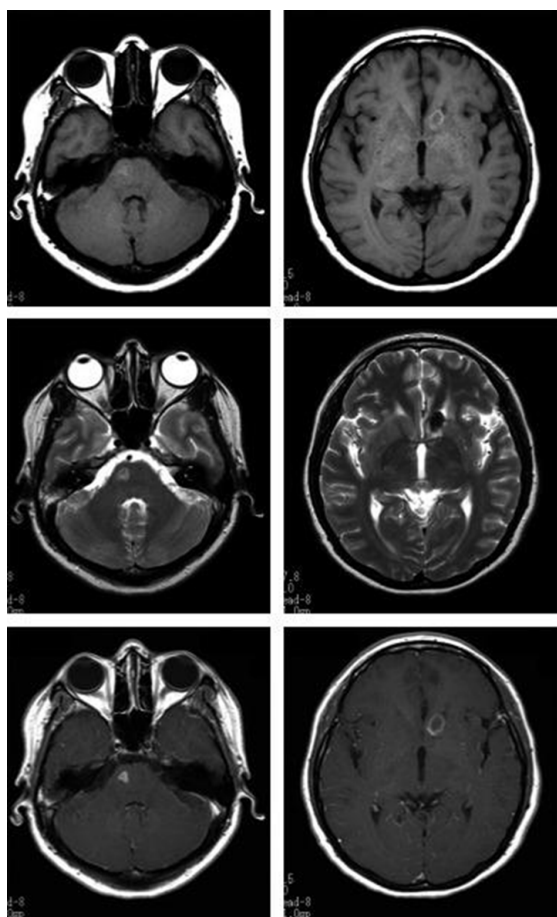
CT scan of the brain showing multiple ring-enhancing lesions, a hallmark of neurocysticercosis. The MRI shows multiple cystic lesions with ring enhancement, consistent with neurocysticercosis, indicating active inflammation around cysticerci in the brain.
